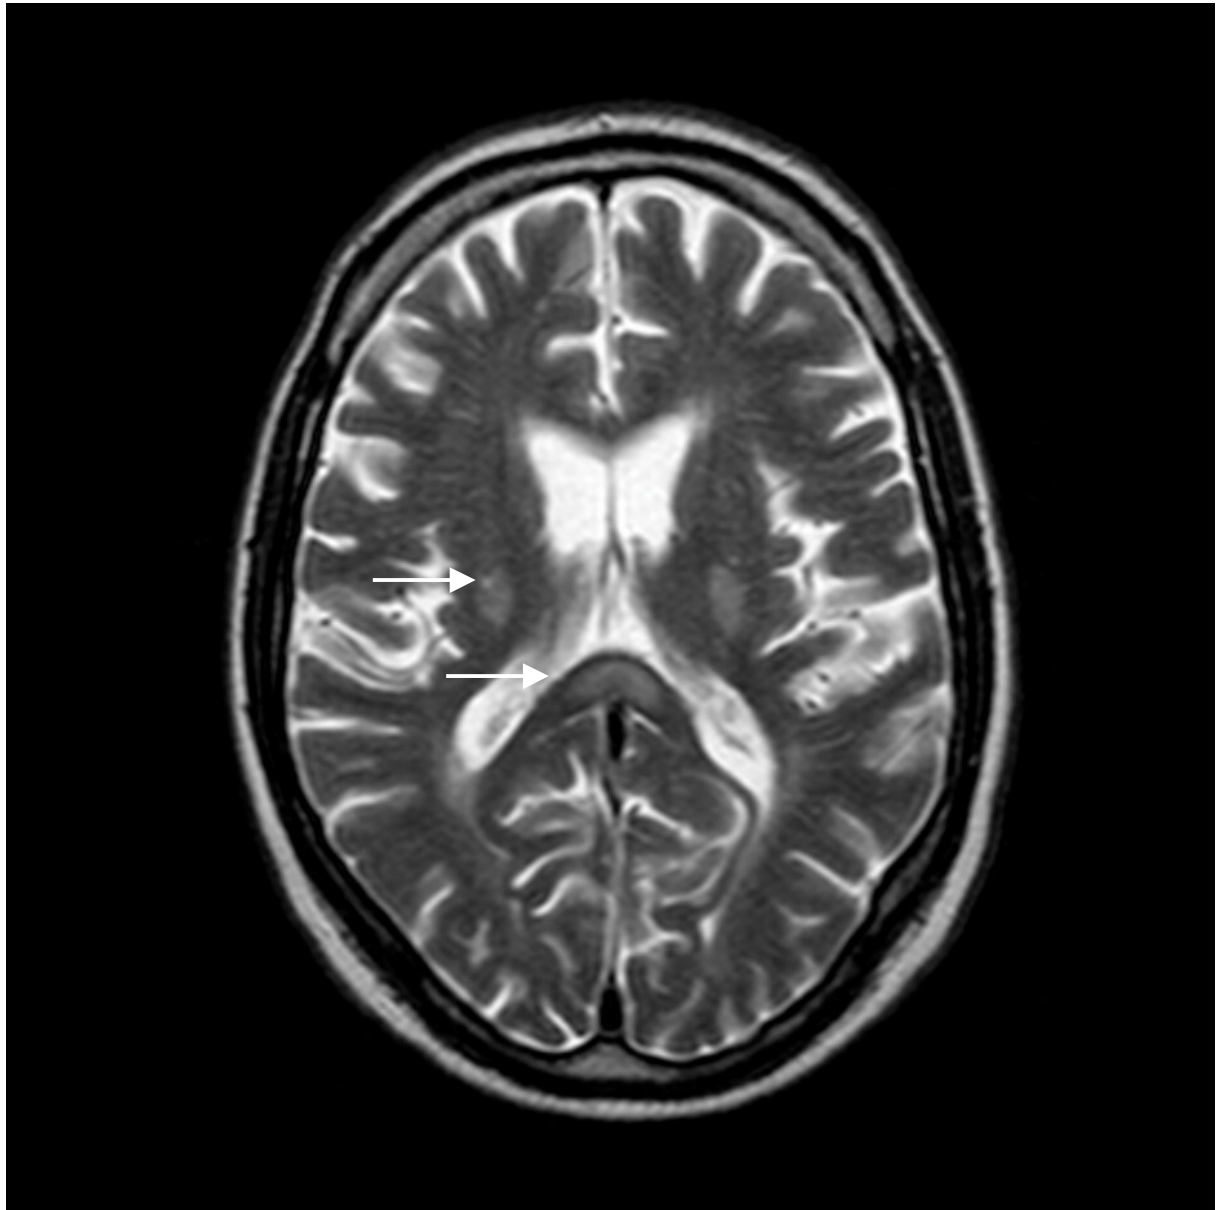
T2-weighted axial image in Marchiafava-Bignami disease showing a high signal lesion in the corpus callosum and internal capsule (arrowed)
